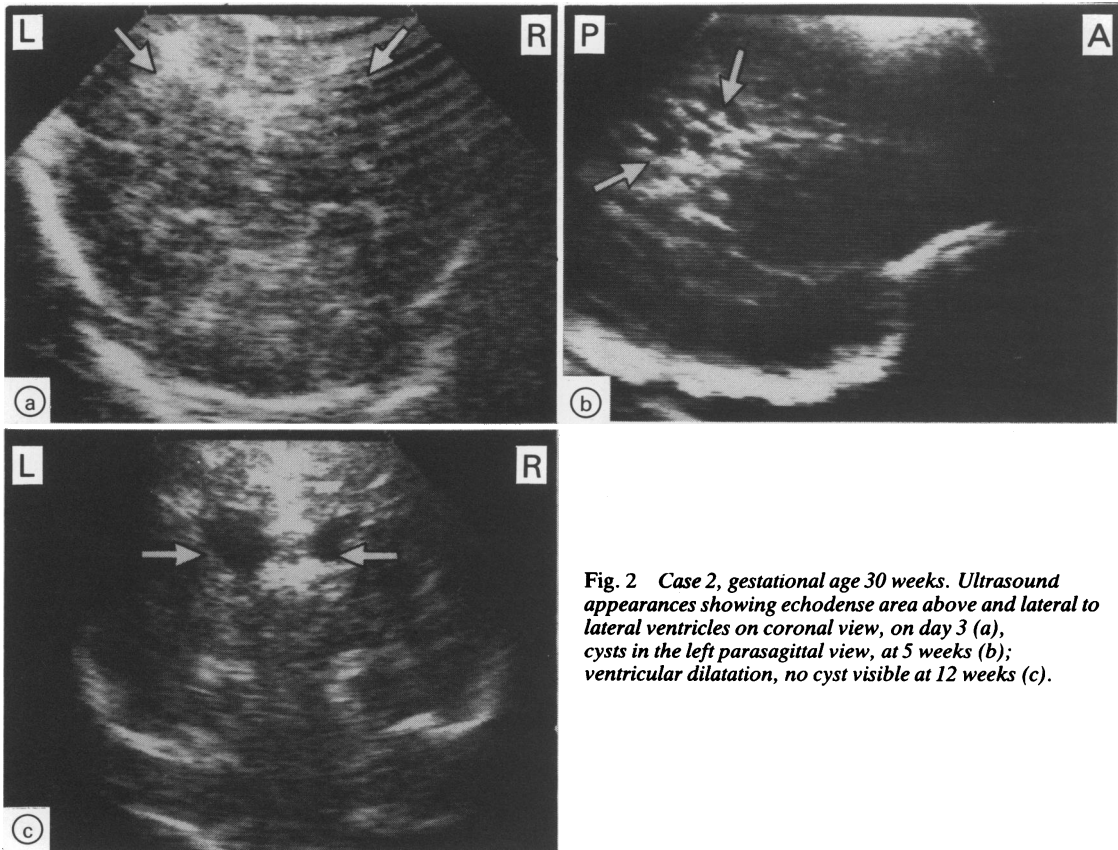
Case 2, gestational age 30 weeks. Ultrasound appearances showing echodense area above and lateral to lateral ventricles on coronal view, on day 3 (a), cysts in the left parasagittal view, at 5 weeks (b); ventricular dilatation, no cyst visible at 12 weeks (c).
